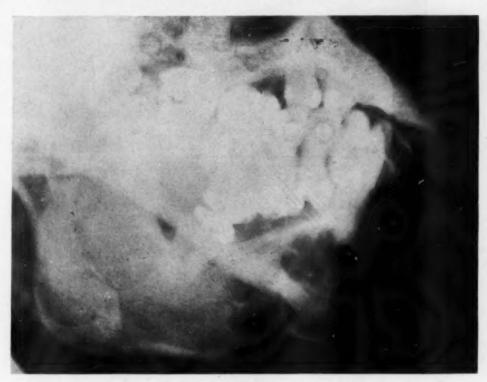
X-ray showing polycystic tumor of the mandible.
